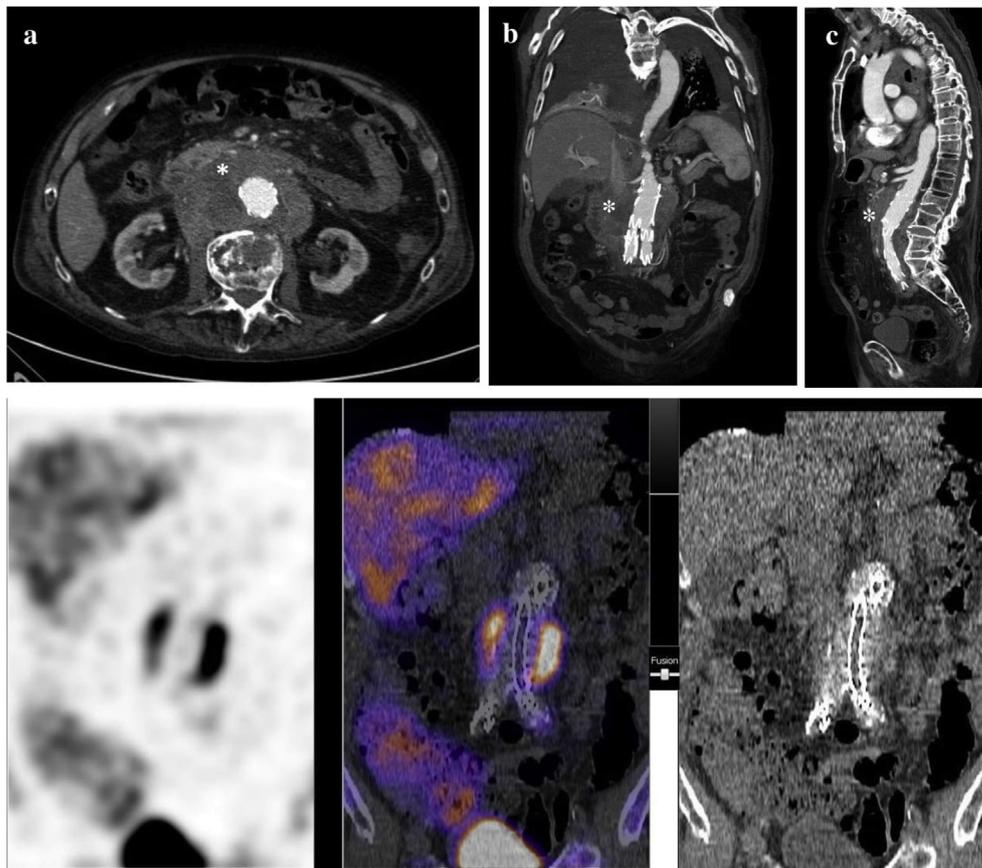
Above: Graft infection in a patient with an aortoiliac graft. Axial CTA image (a) shows an area of soft tissue attenuation (asterisk) around aortic graft. Coronal (b) and sagittal (c) images show the exact cranio-caudal extension of the perigraft collection (asterisk). Below: Graft infection in a patient with an aortoiliac graft. SPECT taken 24 hours after administration of radiotraced WBC (left) demonstrate a focal high-level site of radiotracer activity. The exact localization is possible thanks to the co-registration of CT image (SPECT/CT middle, CT right), Confirming the diagnosis of AGI.
